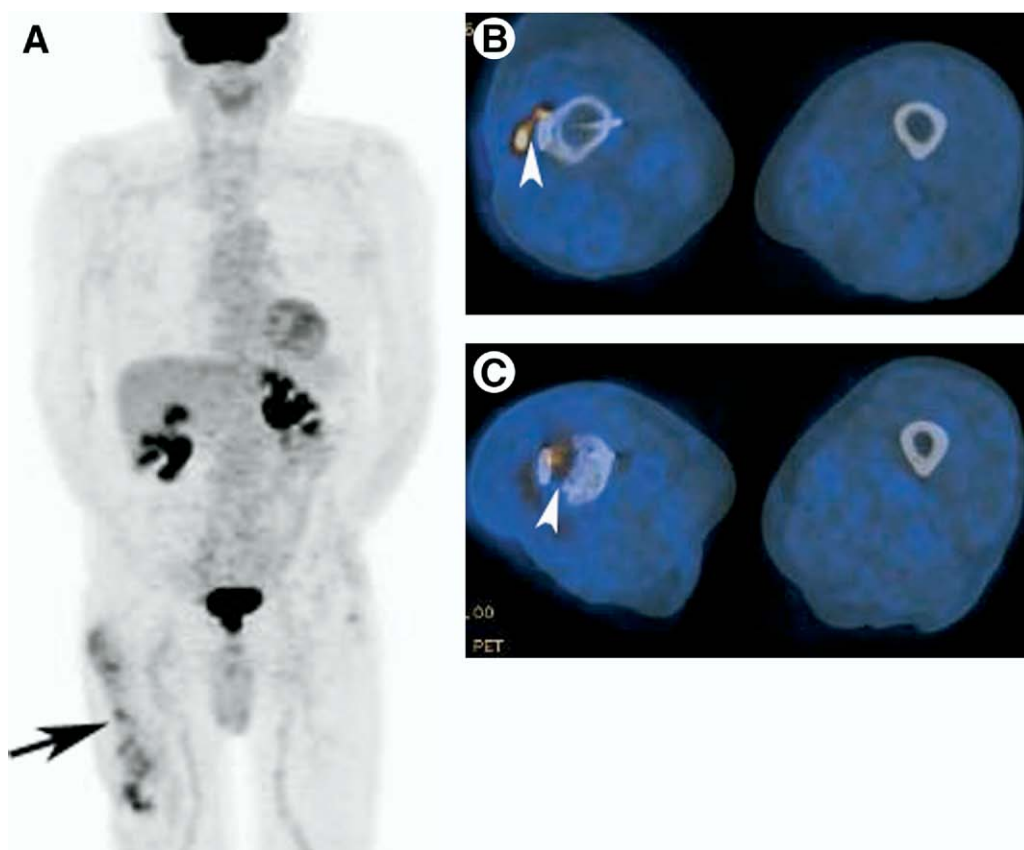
A 72-year-old man with suspicion for metallic implant associated infection of the right femur is shown. The patient had a history of chronic osteomyelitis in the past as the result of undergoing surgery for liposarcoma of the right thigh. (A) MIP shows increased FDG uptake around the metallic implant in the right lateral femur (black arrow). Axial PET/CT demonstrates focally increased FDG along the metallic material and the adjacent femur (B and C, white arrows). Diagnosis of an infected metallic implant with osteomyelitis was established.
